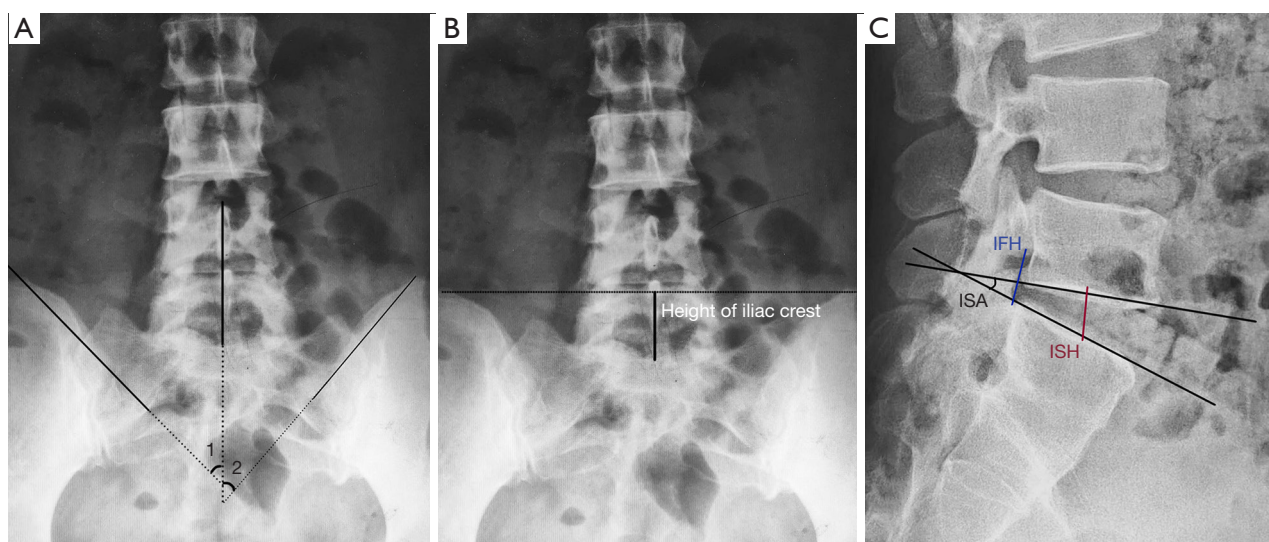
Measurement of the different radiographic variables. (A) Median iliac angle. (B) Height of iliac crest. (C) L5/S1 ISA, IFH and ISH. ISA, intervertebral space angle; IFH, intervertebral foramen height; ISH, intervertebral space height.
